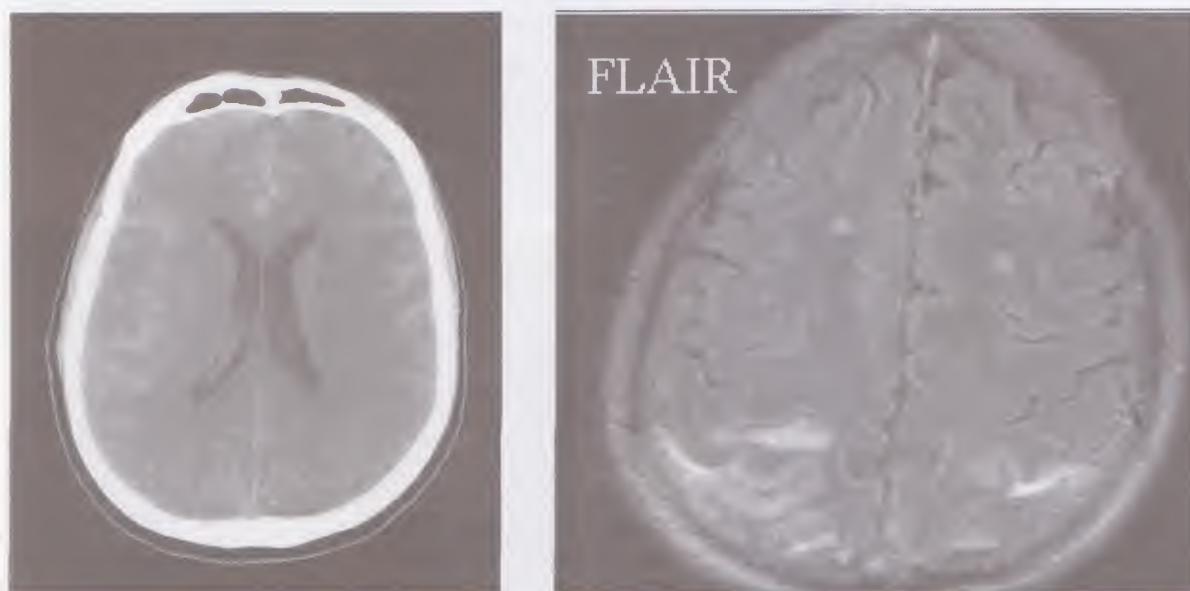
Subarachnoid hemorrhage; CT brain (the left image) with increased density in brain sulci denoting subarachnoid hemorrhage. MRI brain, FLAIR (fluid-attenuated inversion recovery) image (the right image) showing hyper-intensity in the parietal lobe.
